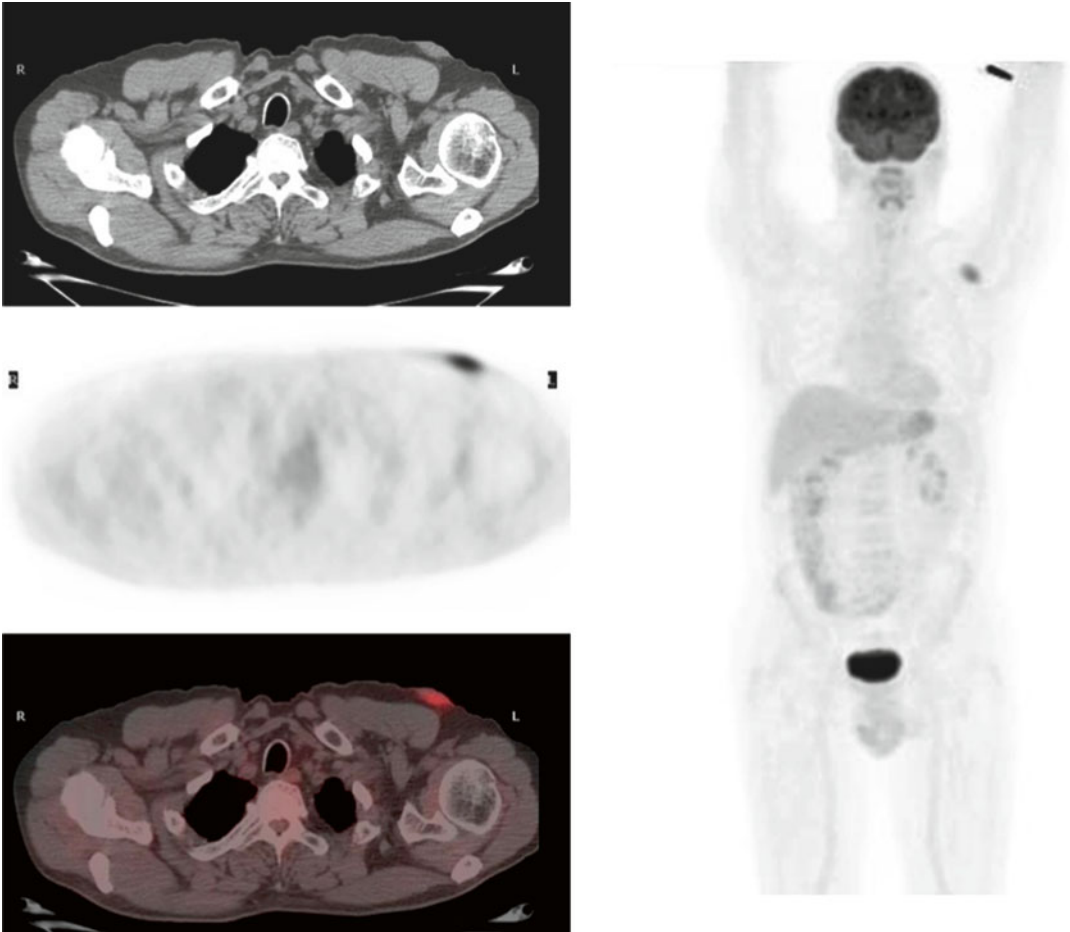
CT, 18-FDG-PET, fused PET/CT, and MIP-PET images reveal the presence of hypermetabolic cutaneous nodule of the left thoracic wall. No other lesions of abnormal increased uptake of the radiopharmaceutical are observed
